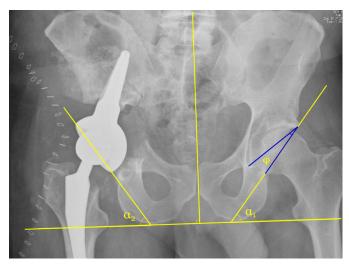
Measurement of inclination (INCL) and anteversion (AV) on preoperative anteroposterior radiographs.
